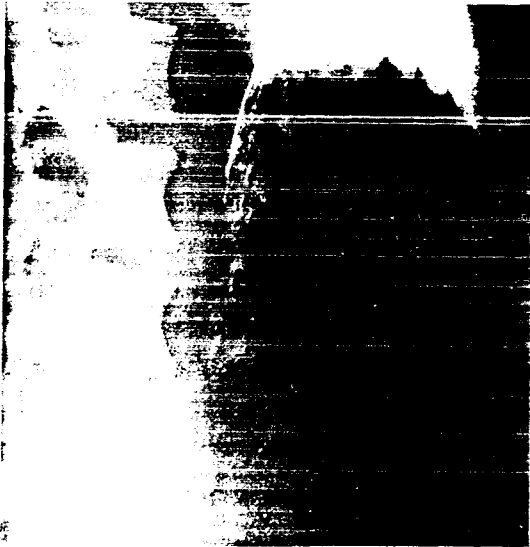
After barium meal a large intragastric mass could be seen at abdominal roentgenogram.
